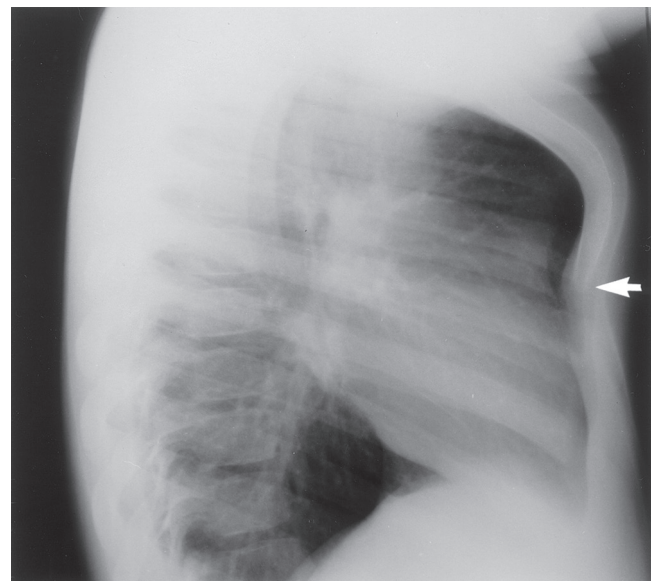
■ Lateral chest radiograph of a boy with chondromanubrial pectus carinatum. The short, comma-shaped sternum lacking segmentation is apparent. Arrow is at the tip of the truncated sternum. (From Shamberger RC, Welch KJ: Surgical correction of chondromanubrial deformity [Currarino Silverman syndrome]. *J Pediatr Surg* 23:319–322, 1988. With permission.)
